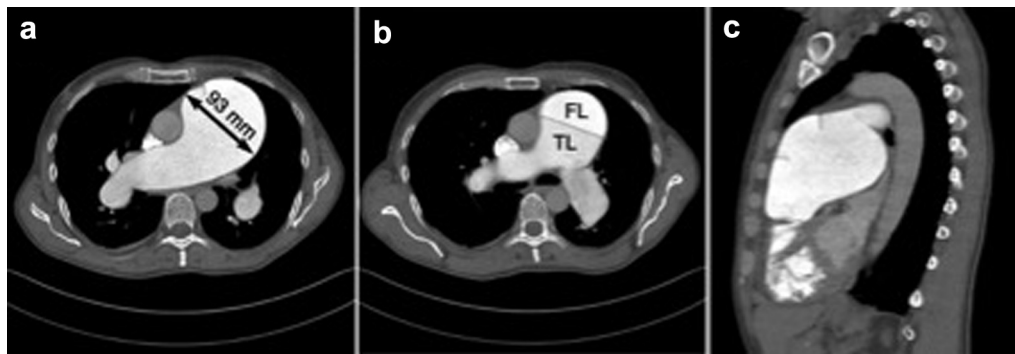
(a) Preoperative CT-scan demonstrating an aneurysm of the pulmonary artery (PA). In the ventral medial portion of the aneurysm is a small flap of the dissection membrane seen. (b) Preoperative CT-scan demonstrating a dissection of the pulmonary artery (PA). False (FL) and true lumens (TL) are seen. (c) Sagittal view showing the pulmonary valve and the proximal and distal dissection membranes in the ventral wall of the aneurysm of the pulmonary artery.
